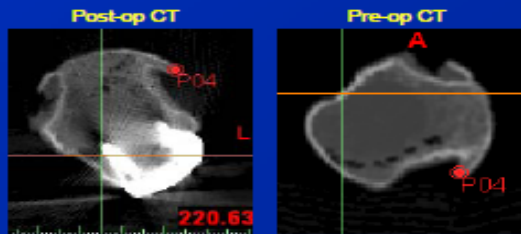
To register post-op CT onto Pre-op CT, three or more pairs of points (same location on the two CT sets, i.e. P04) need to be matched.
